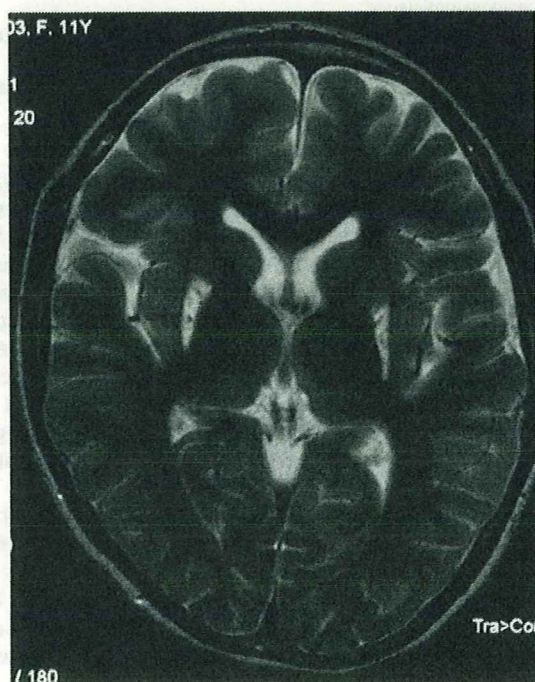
T2-weighted magnetic resonance imaging (MRI) of the brain of the patient at 11 years of age.
